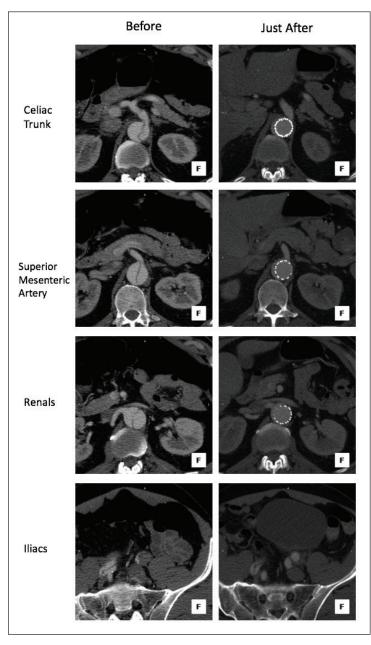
Images of a patient treated for acute complicated TBAD with the STABLE technique. In the left column, slices of the preoperative CTA show collapse of the true lumen along the aorta beyond the thoracoabdominal junction. In the right column, slices of the immediate postoperative CTA exhibit a satisfying opening of the true lumen scaffolding by the bare-metal stent toward the abdominal aorta.
